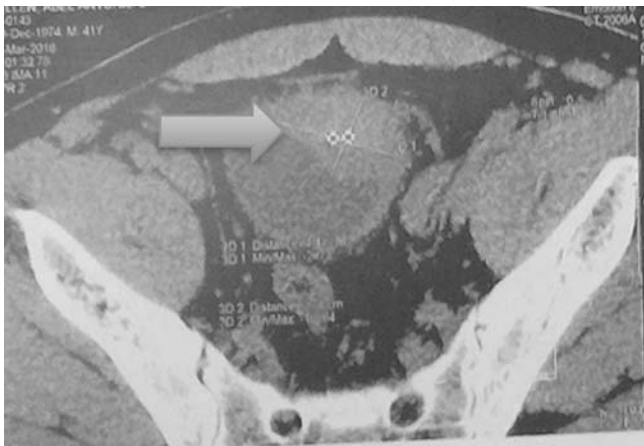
Initial CT stonogram shows a heterogenous mass at the left anterolateral side of the urinary bladder (arrow)
